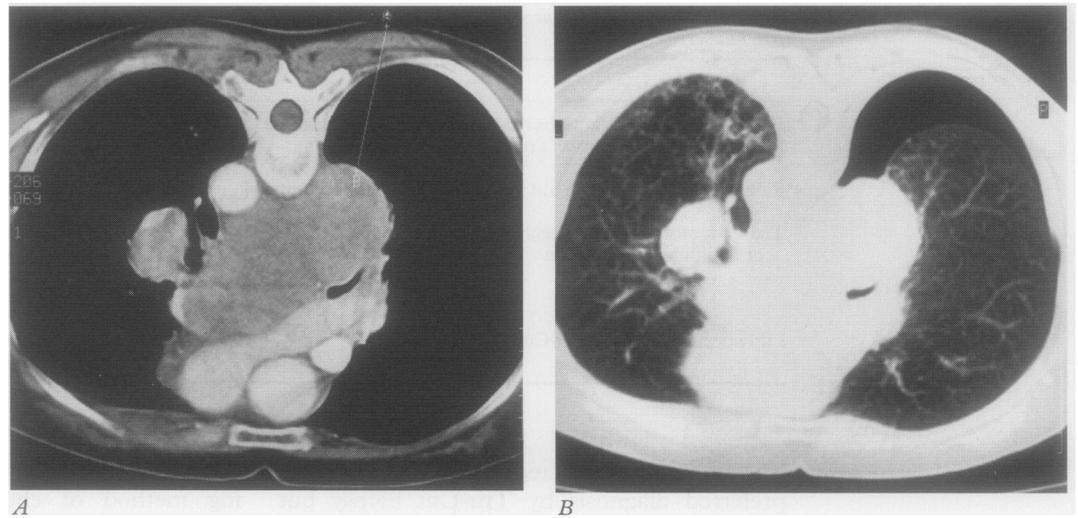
Biopsy of a middle mediastinal mass: patient prone, right posterior approach. (A) The planned biopsy route crosses two pleural surfaces in order to access enlarged subcarinal lymph nodes (CT window width (WW) 400 Hounsfield units (HU), window level (WL) + 20 HU). (B) Scan immediately after the procedure showing a moderate pneumothorax (WW 850 HU, WL - 750 HU).
